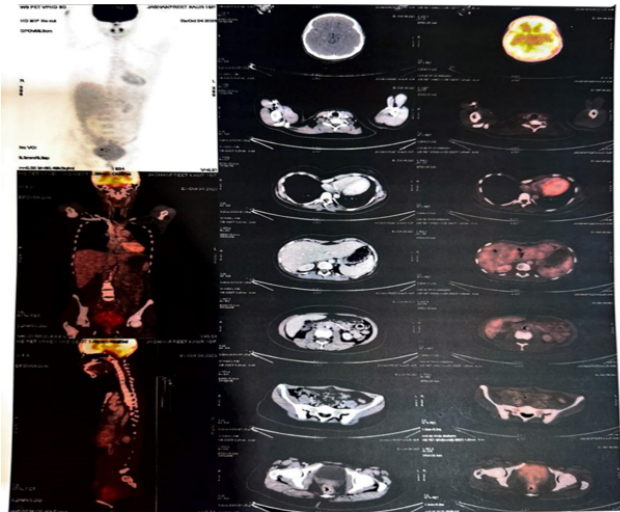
PET CT scan showing minimally metabolic small cystic lesion in right adnexal region measuring ~1.3*1.0 cm. Post surgery inflammatory changes seen in lower anterior abdominal wall with focal nodular thickening along peritoneum.
